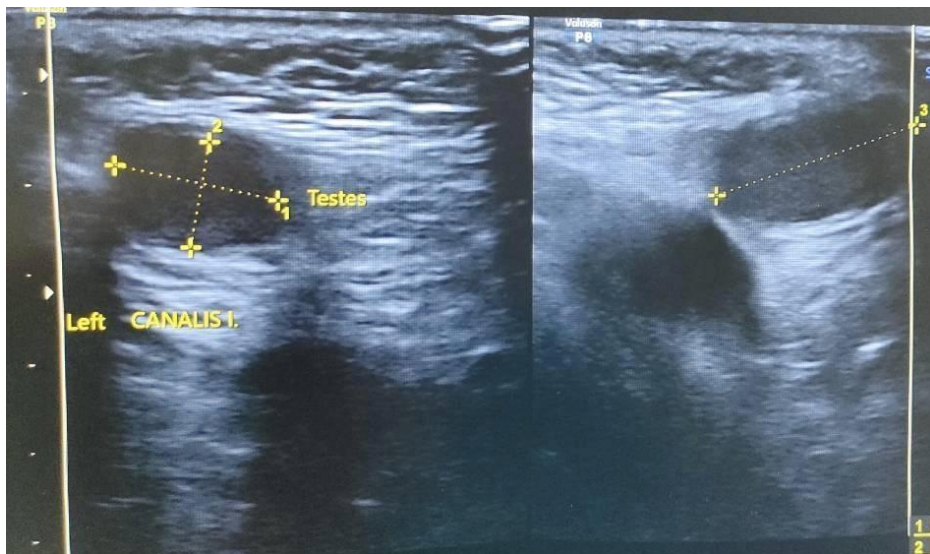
Ultrasound examination of left testicle
